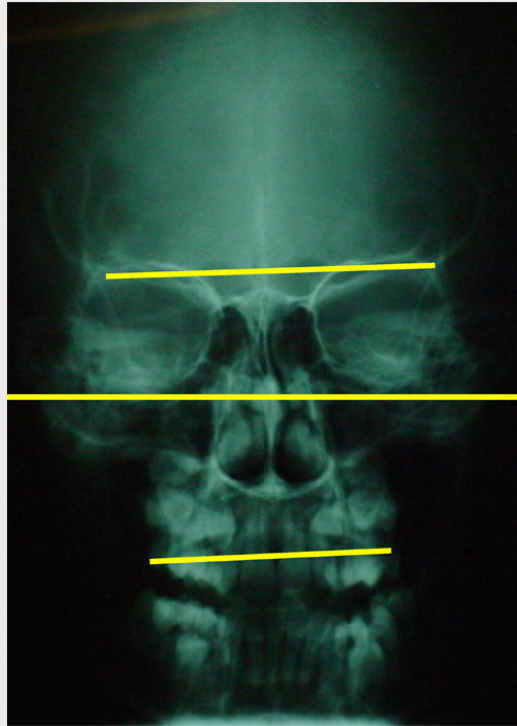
A PA cephalometric radiograph of the skull marking three planes through the fronto zygomatic sutures, the glenoid fossae and the maxillary occlusal plane showing a roll distortion in the cranium. These planes can be identified clinically
